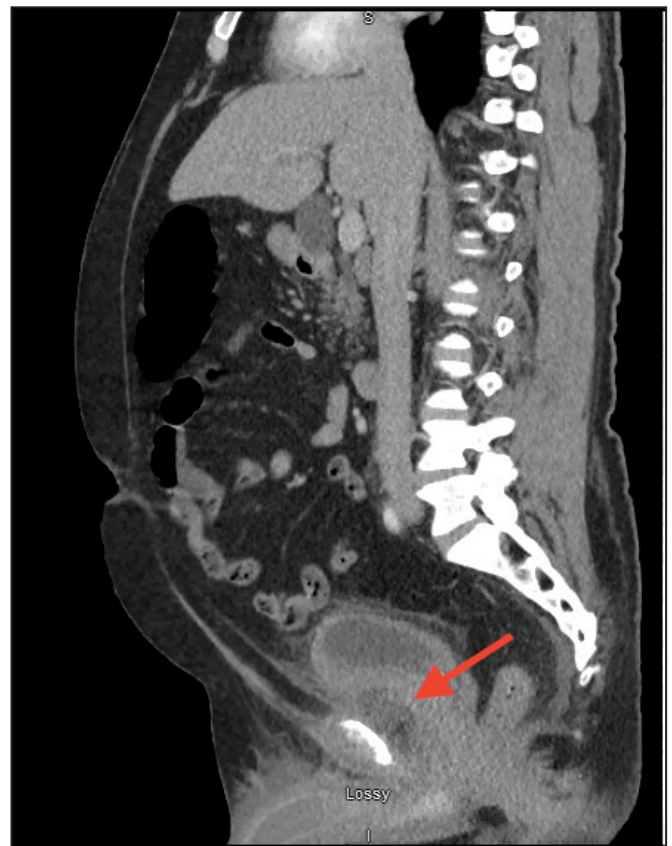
Sagittal CT image of enhancing fluid collection with adjacent fat stranding anterior to the bladder
